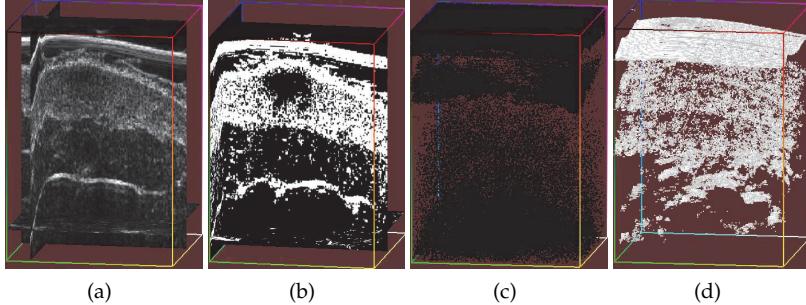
a) One ultrasound image, b) The same ultrasound image after a binarization, [c-d] Connected components extracted from different binary images
